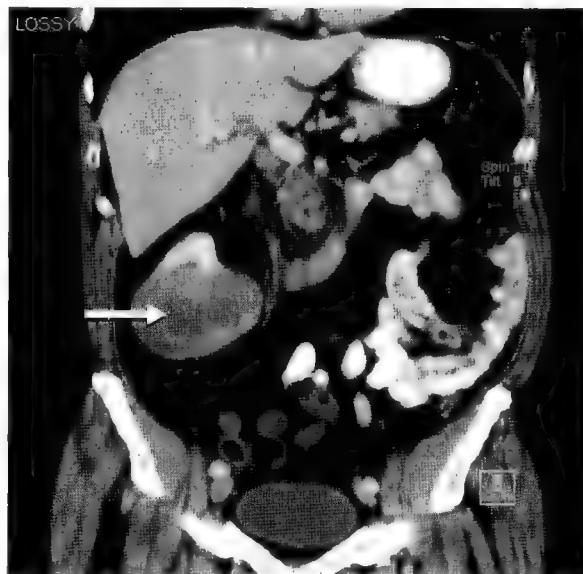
CT scan after contrast infusion showing large mass replacing lower pole of right kidney (arrow), suggestive of renal cell carcinoma. Note that the left kidney is not seen in this section plane.
